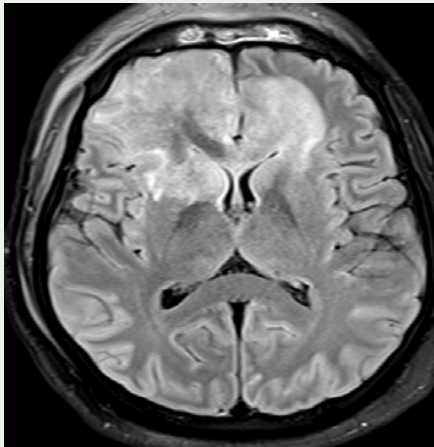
MRI Brain - Orbital cellulitis and basifrontal acute infarct.
